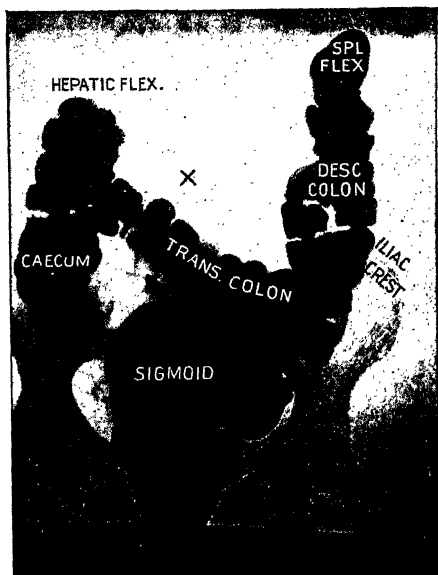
Normal Radiograph of Large Intestine Particularly Well Filled from End to End. (Barclay, *Digestive Tract*, Cambridge)
